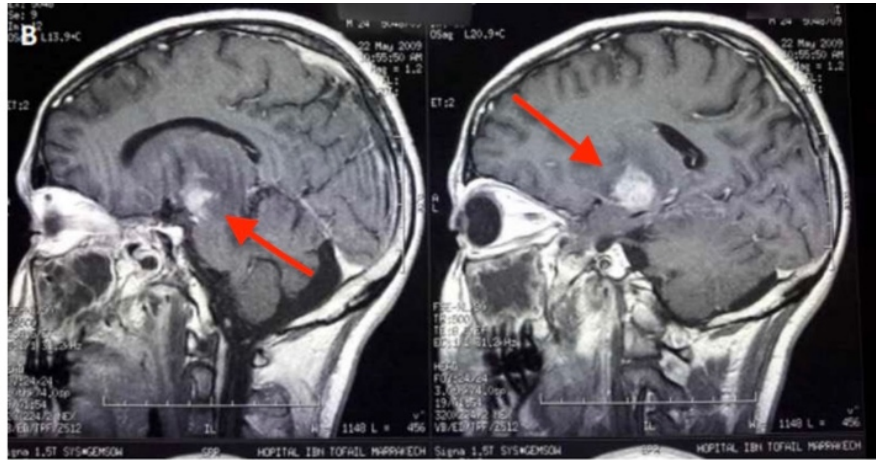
Brain MRI showing sagittal T1-weighted images with contrast enhancement of a mesencephalo-diencephalic lesion with a crown of edema and little mass effect.
